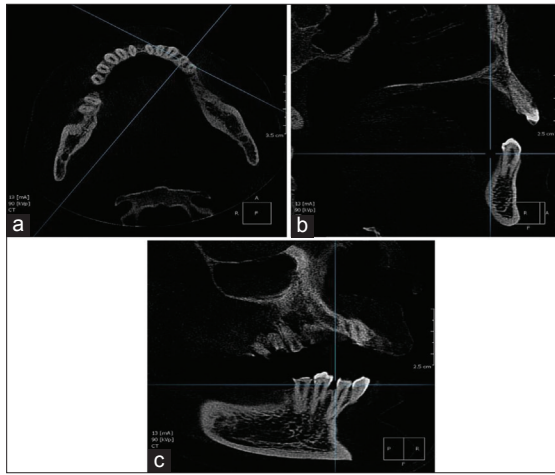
Cross-sectional cone-beam computed tomography images of mandibular first premolar with clearly distinguished two roots and canals in a male person. (a) Axial plane, (b) sagittal plane, (c) coronal plane
